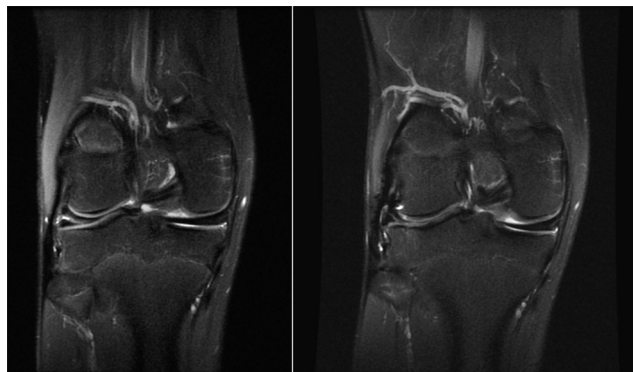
Preoperative and 2-year postoperative MRI for the same patient; persistence of a grey, hyperintense signal (type III).
